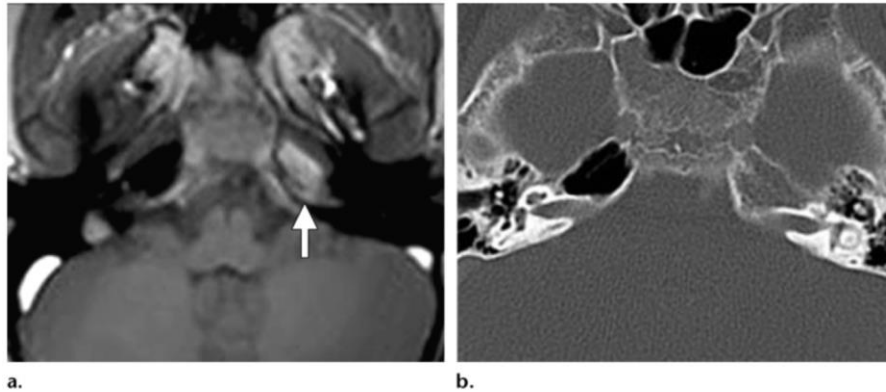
Asymmetric petrous apex pneumatization mimicking a lesion. (a) Axial unenhanced T1-weighted MR image shows asymmetric high signal intensity in the left anterior petrous apex (arrow), a finding that might be mistaken for a cholesterol granuloma or soft-tissue mass. (b) Corresponding CT image shows that the right petrous apex is pneumatized. Therefore, it is evident that the high signal intensity in the left petrous apex in a simply represents normal fatty marrow in nonpneumatized bone. Note the normal bone trabeculae in the left anterior petrous apex.
